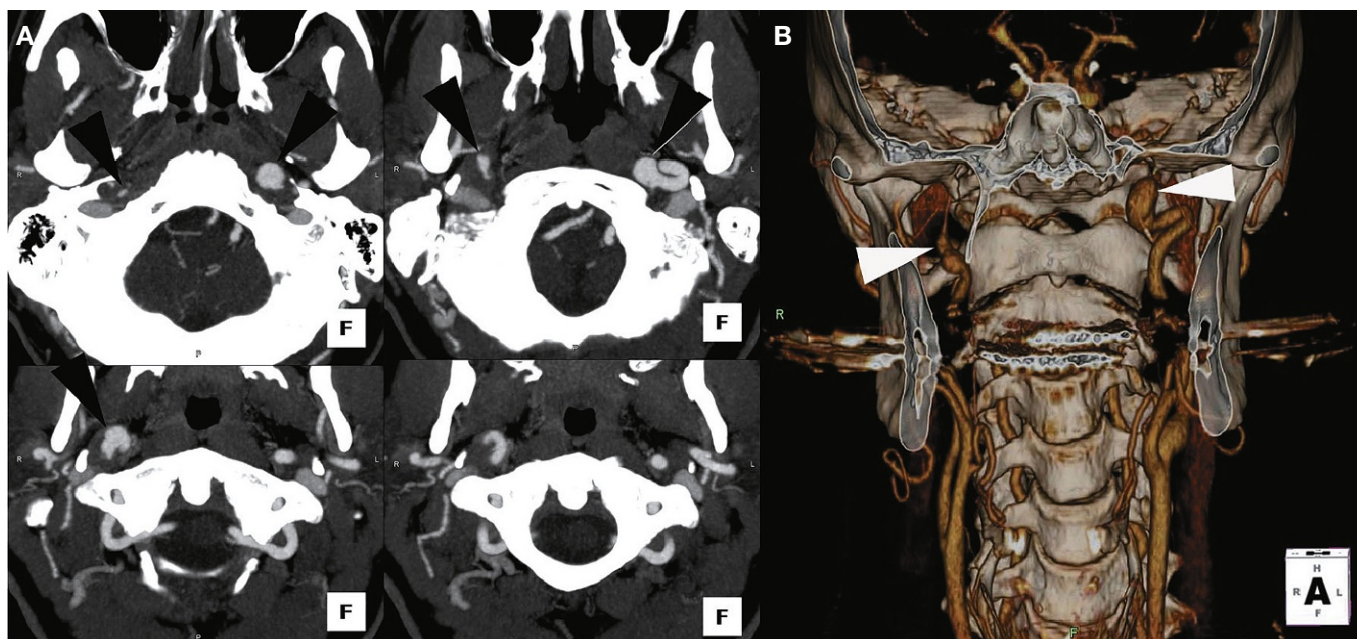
A 50-year-old male patient who suffered several falls while snowboarding. Because of transient ischemic attack symptoms, the patient underwent a computed tomography angiogram (CTA). This CTA demonstrated bilateral internal carotid artery pseudoaneurysms (associated with a dissection on the right side) just below the skull base. This segment of the internal carotid arteries is particularly vulnerable to shear trauma forces, because it is a mobile segment adjacent to an immobile segment in the petrous portion of the carotid canal.
